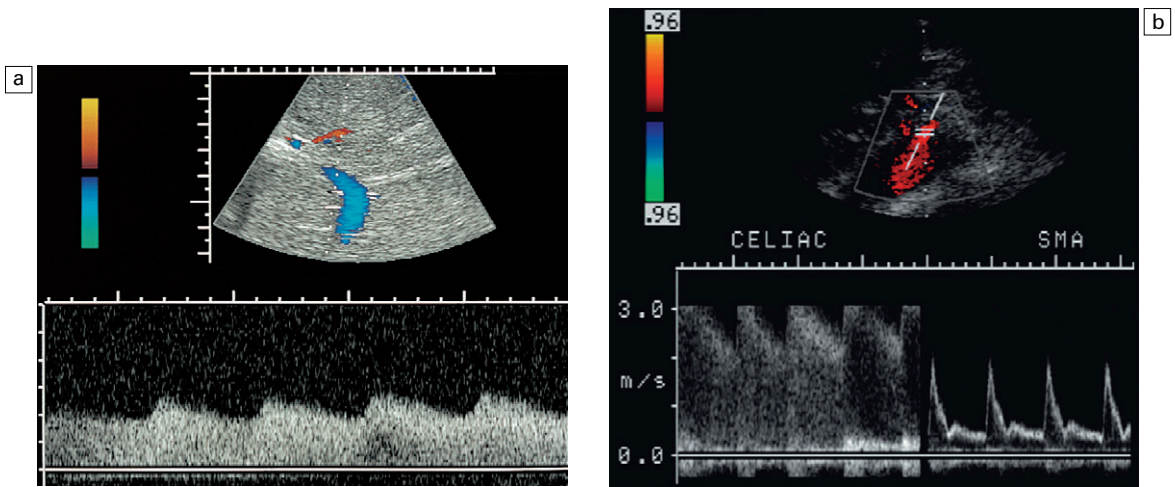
(a) Spectral Doppler tracing of an hepatic artery in a young patient with upper abdominal pain. The waveform shows a markedly tardus parvus configuration. There is a slow upstroke in systole and very low resistive index. This indicates inflow compromise. (b) Combined spectral Doppler tracing of the celiac artery and superior mesenteric artery (SMA) shows a normal flow velocity in the SMA. The celiac artery, however, shows a very turbulent waveform with a velocity greater than 3 m s^{-1} . MR angiography confirms celiac artery compression by the arcuate ligament of the diaphragm.
